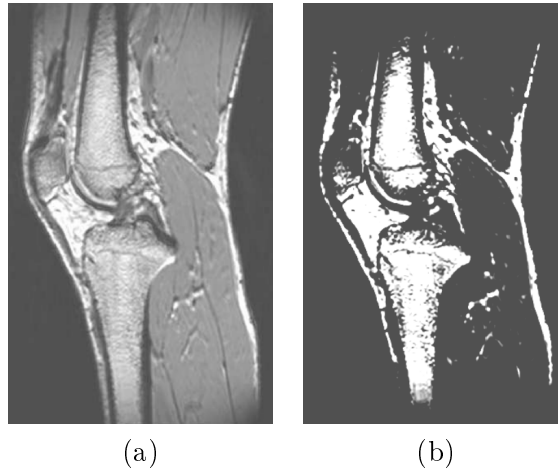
MR image of a knee (a) before and (b) after bone segmentation using two thresholds. Note that fat tissue is also segmented, since its appearance in the MR image is close to spongy bone tissue.
